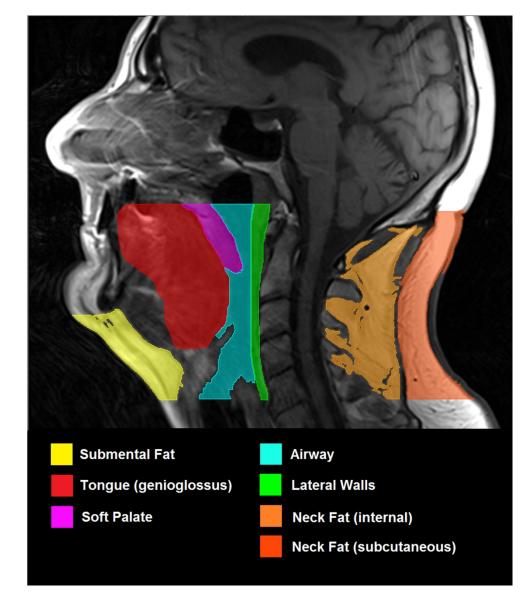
Magnetic resonance imaging (T1 weighted, spin-echo, 4mm slice thickness) showing the midsagittal slice of head and neck. Region of interest includes all tissue inferior to hard palate and superior to vocal cords. The following structures to be included in analysis have been highlighted: Submental fat, defined as all fat anterior to hyoid and inferior to mandible; tongue (genioglossus); soft palate; airway; lateral parapharyngeal walls; internal neck fat; subcutaneous neck fat.
